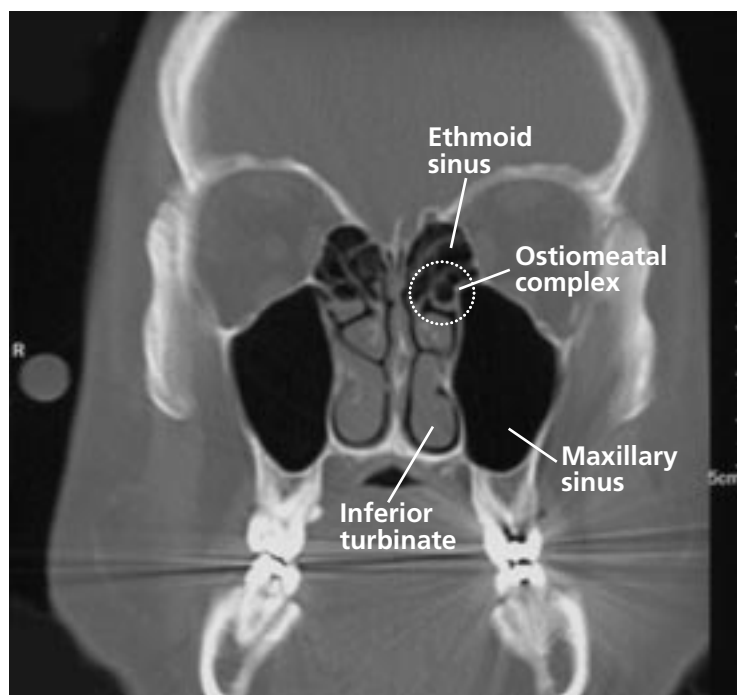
Computed tomographic scan of the sinuses, coronal view. The maxillary, anterior ethmoid, and frontal sinuses all drain into the ostiomeatal complex, which is easily obstructed.
